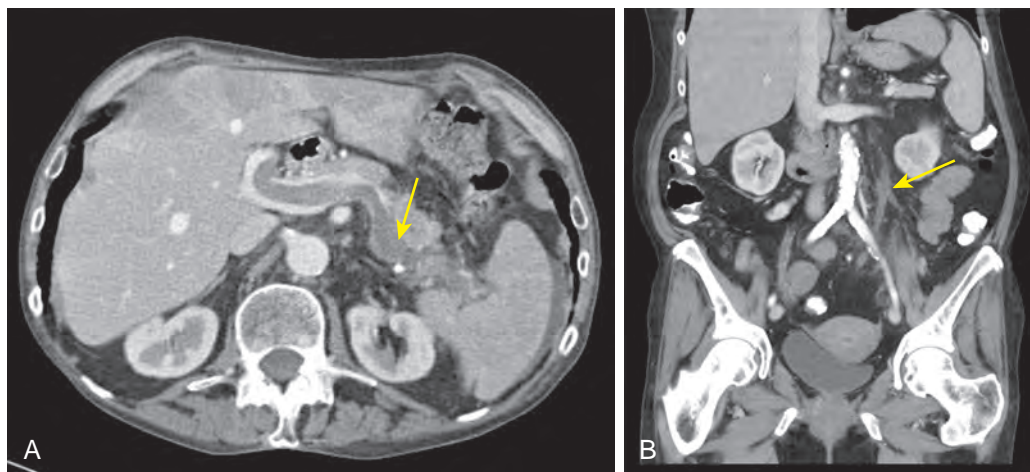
Splanchnic venous thrombosis. A. Low-density thrombus (arrow) is present within the splenic vein propagating into the portal vein in this patient with a coagulopathy. B. Inferior mesenteric vein thrombus (arrow) is depicted on this coronal reformatted CT image in a patient with diverticulitis.
